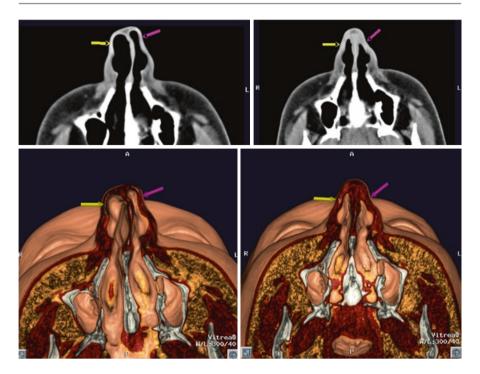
CT axial scans of the previous case with evidence of the septal deformity and laterodeviation of the pyramid
